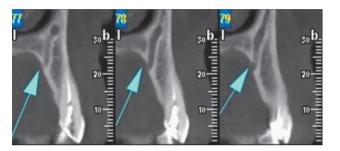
Evaluation of extension of CS in sagittal view of CBCT.
